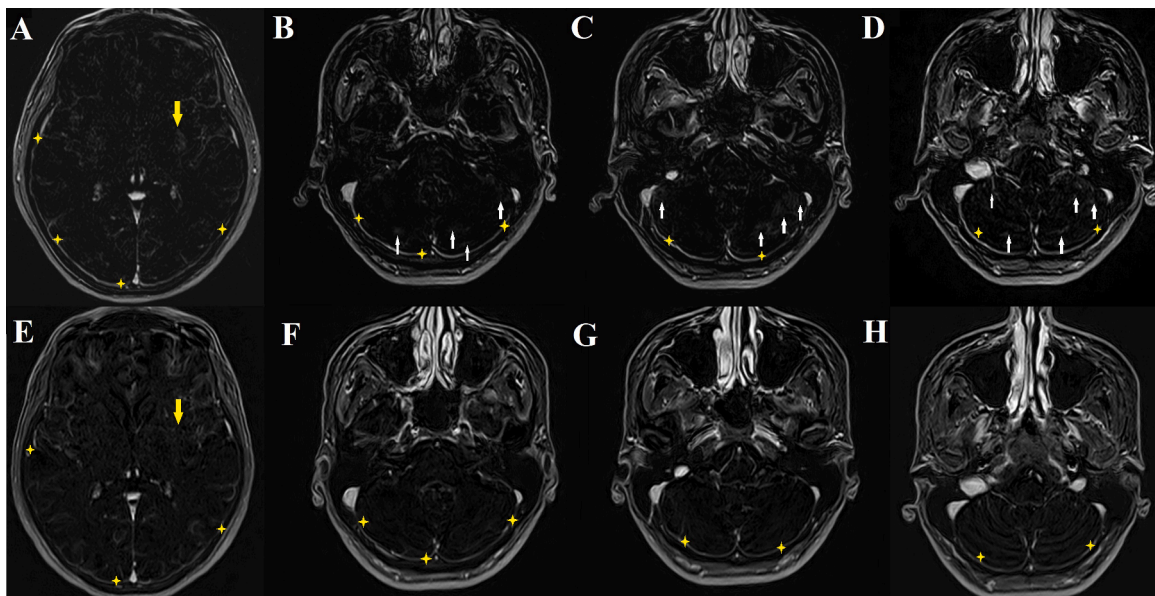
Axial contrast-enhanced T1-weighted subtraction maps. Initial MRI scans (A–D) demonstrate moderate bilateral, mixed pachymeningeal and leptomeningeal contrast enhancement, affecting temporo-parieto-occipital regions extending down into cerebellum (yellow asterix) consistent with pachyleptomeningitis, and also abnormal enhancement within left posterior putamen (yellow arrow) that correspond to pre-contrast T2/FLAIR images (Fig. A–C). Follow-up MRI performed 2 weeks later (E–H) shows persistent subtle contrast enhancement (yellow asterix) and no enhancement within left putamen (yellow arrow).
